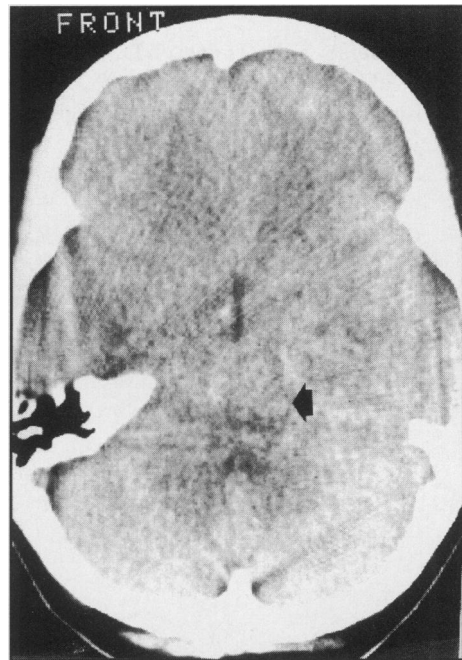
Axial CT scan showing compression of the third ventricle and obliteration of the left ambient cistern. Arrowhead shows position of right ambient cistern which is also compressed.
